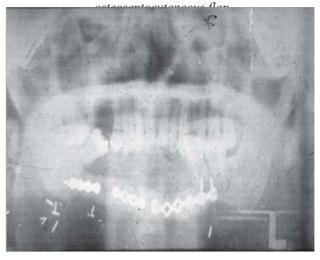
Ortopan radiograph of the lower jaw after
